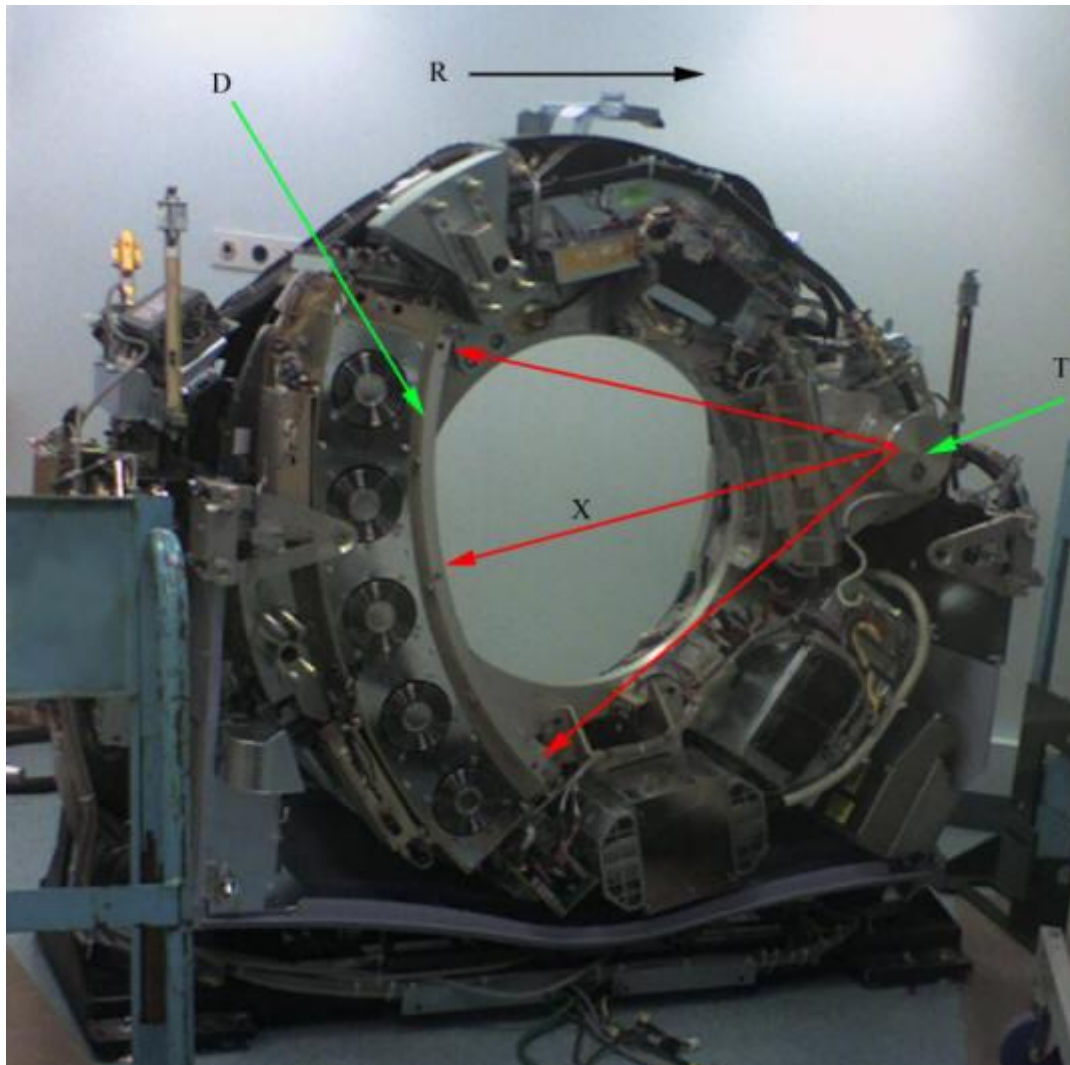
A CT scanner with the covers off (Image by ChumpusRex, Wikimedia Commons.)
